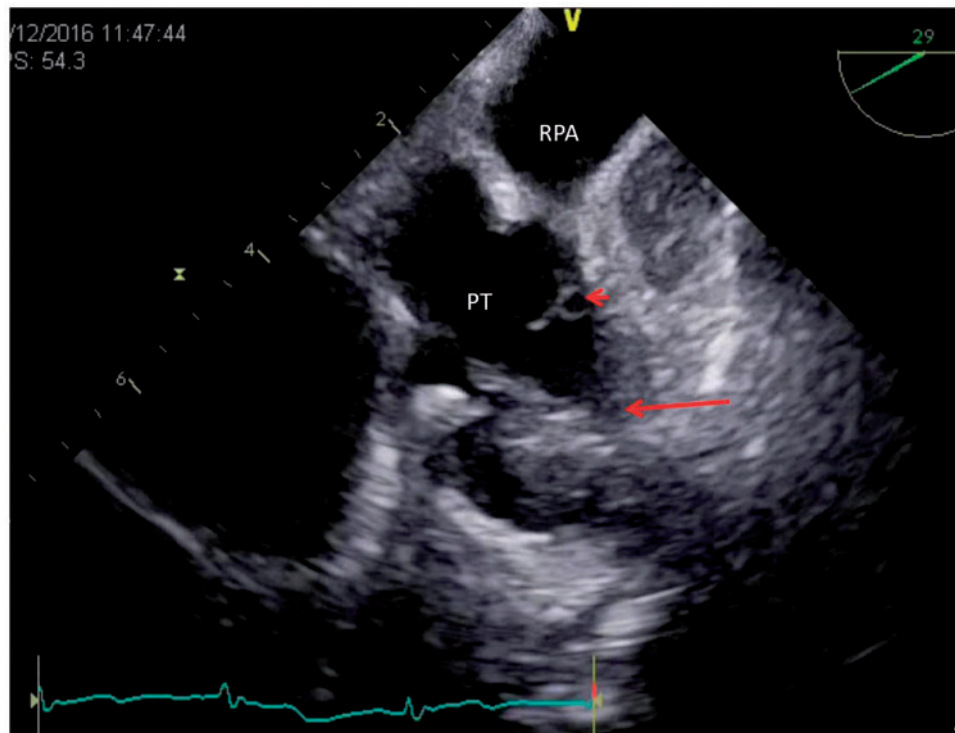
Transoesophageal echocardiogram. Red arrow-head pointing to a filamentous structure arising from the PT and red arrow pointing to the mobile mass arising from the pulmonary prosthesis. PT, pulmonary trunk; RPA, right pulmonary artery.
